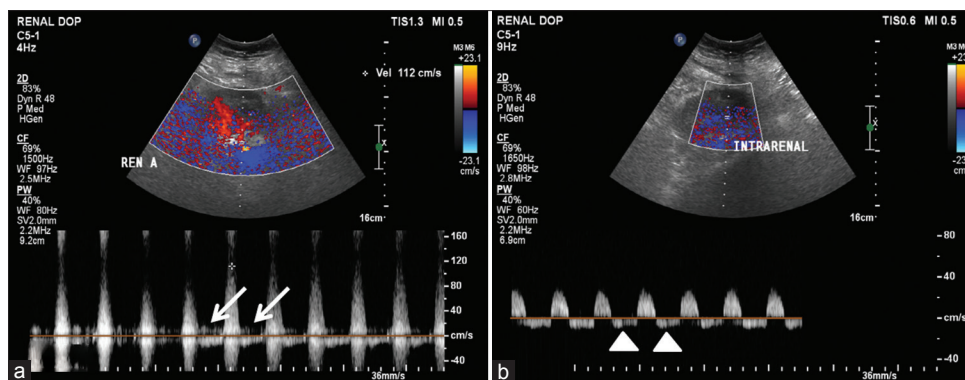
Emergency renal Doppler images demonstrating a high-resistance flow pattern (resistance index ≥ 1) in transplanted renal artery (a, with reduced diastolic flow [arrow]) and intrarenal arteries (b, with diastolic reversal [arrowhead]) with normal venous flow
